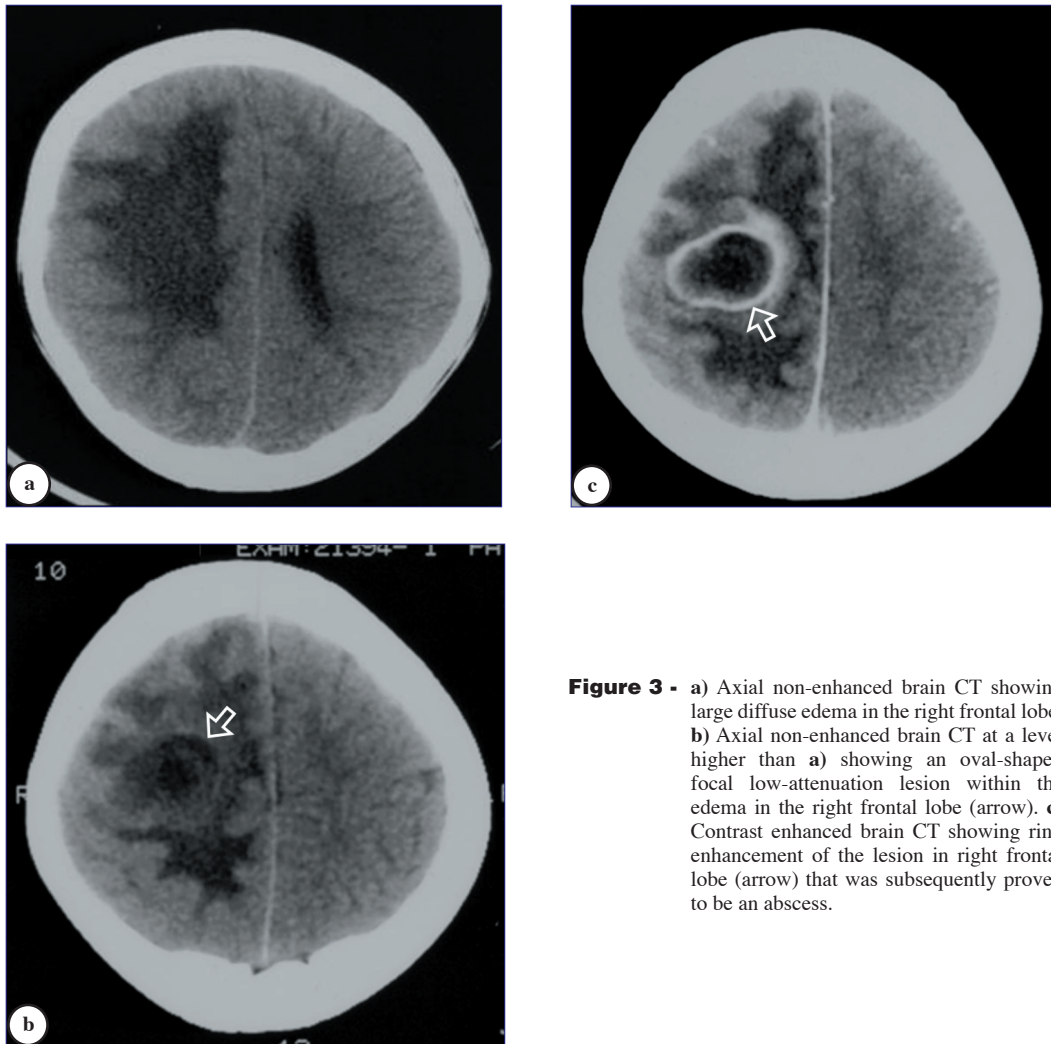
a) Axial non-enhanced brain CT showing large diffuse edema in the right frontal lobe. b) Axial non-enhanced brain CT at a level higher than a) showing an oval-shaped focal low-attenuation lesion within the edema in the right frontal lobe (arrow). c) Contrast enhanced brain CT showing ring enhancement of the lesion in right frontal lobe (arrow) that was subsequently proven to be an abscess.
